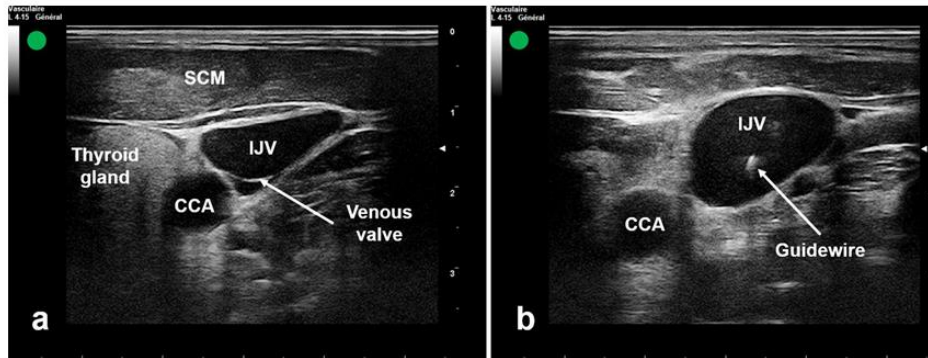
An ultrasound-guided out-of-plane needle approach for an inferior jugular vein (IJV) catheterization employing a short-axis image of the vein. It is possible to see the IJV and CCA on an ultrasound. b Guidewire ultrasound imaging in the internal jugular vein. CCA common carotid artery SCM sternocleidomastoid muscle IJV internal jugular vein
